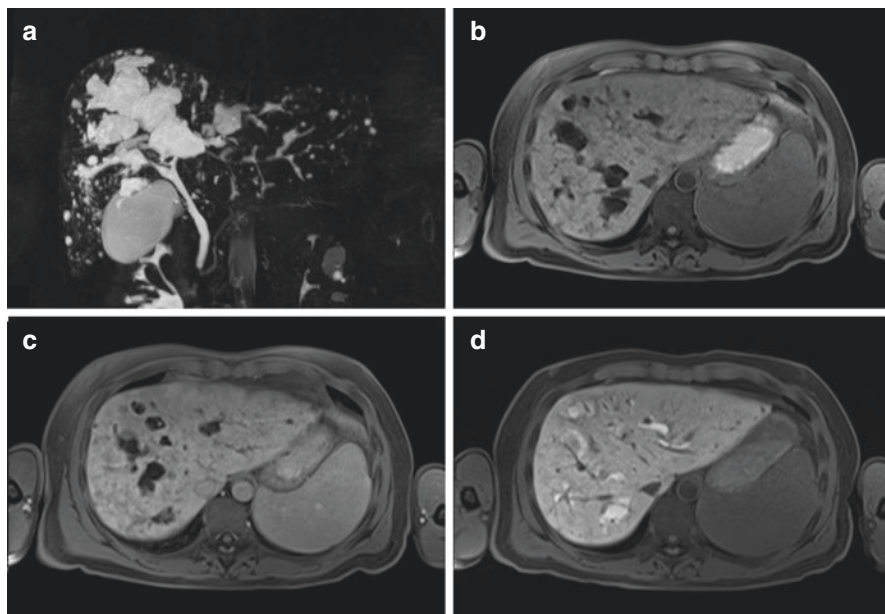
T2-weighted MRCP image showing hyperintense cystic dilatation of the biliary tree (a). T1-weighted transverse images acquired before (b) and after the administration of hepatobiliary contrast agent (gadoxetic acid), depicting “central dot sign” in portal venous phase (c) and lumen contrast enhancement in hepatobiliary phase (d), confirming the communication of the cystic dilations with the biliary tree
